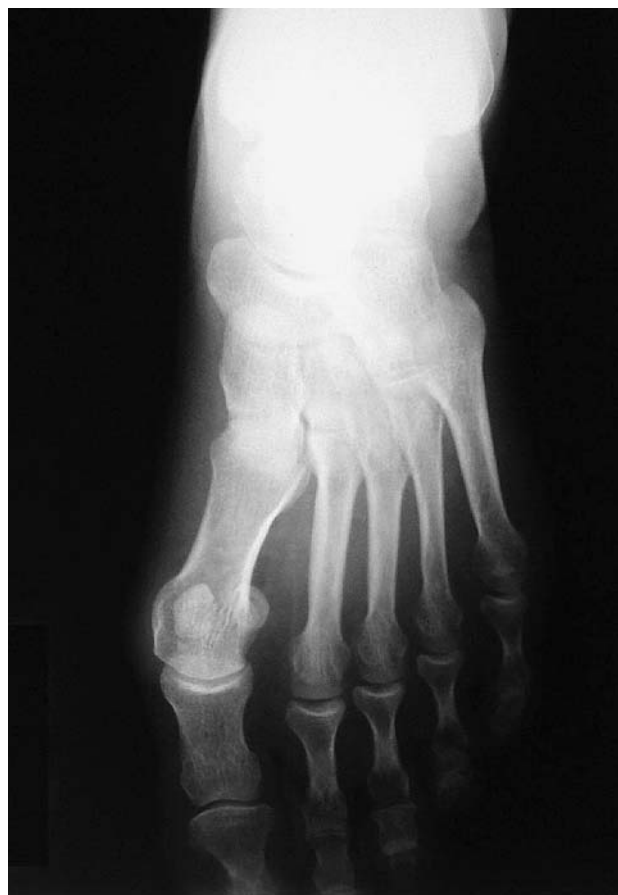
Preoperative AP (anteroposterior) X-ray of the left feet; E S., female, 49 years
